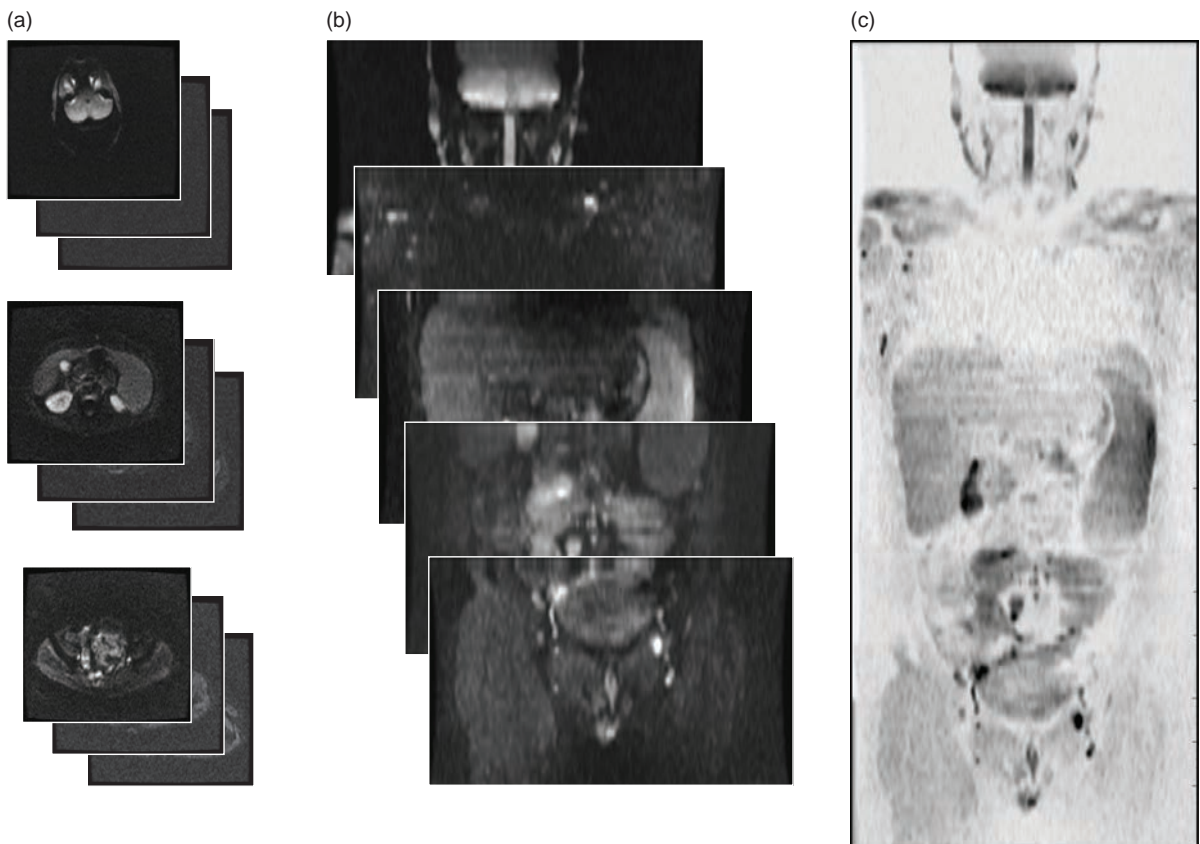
Whole-body diffusion – axial DWI images are acquired (a), then reformatted (b) and stitched together with contrast reversed (c).
